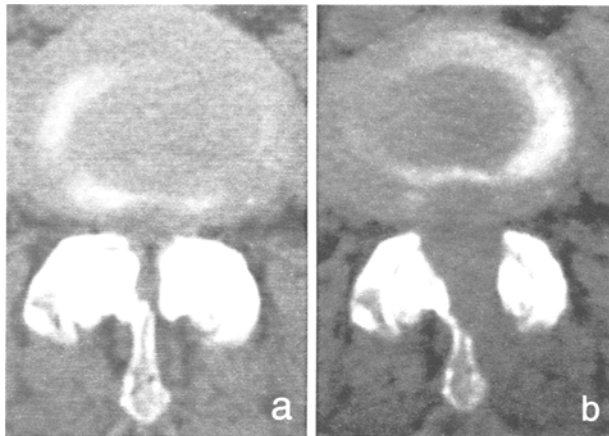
CT-scans showing the level of maximal spinal stenosis. (a) Pre-operative image of a patient with severe neurogenic claudication – walking distance 50 m – and sensory disturbances. (b) Post-operative image 6 days after surgery at discharge demonstrating the left-sided laminotomy and bilateral decompression. The walking distance was markedly improved – over 1000 m – and the sensory disturbances were nearly completely resolved
